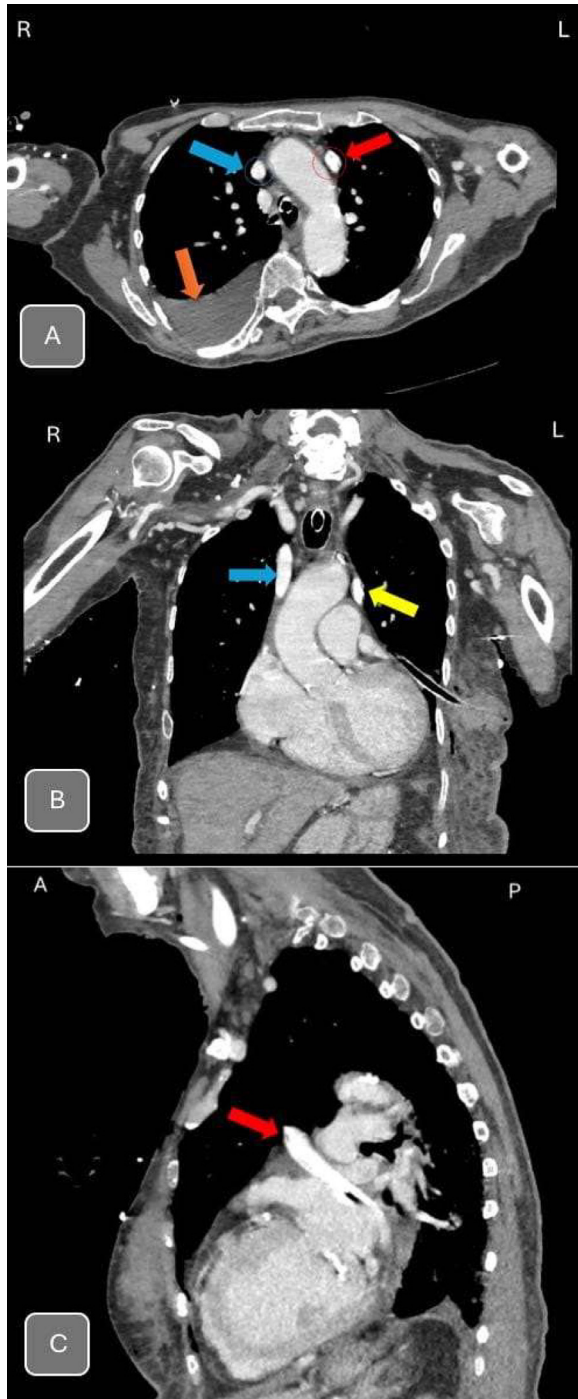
Several views of CT scan with IV contrast. (A) Axial chest CT scan with IV contrast (venous phase) show Double SVC, right sided SVC (blue arrow), Left SVC (red arrow), and right pleural effusion is also noted. (B) Coronal chest CT scan with IV contrast (venous phase) show Double SVC, right sided SVC (blue arrow), and Left SVC (yellow arrow). (C) Sagittal chest CT scan with IV contrast (venous phase), Left SVC is draining into coronary sinus with a central line (red arrow), its distal tip in mid left SVC (away from coronary sinus).
